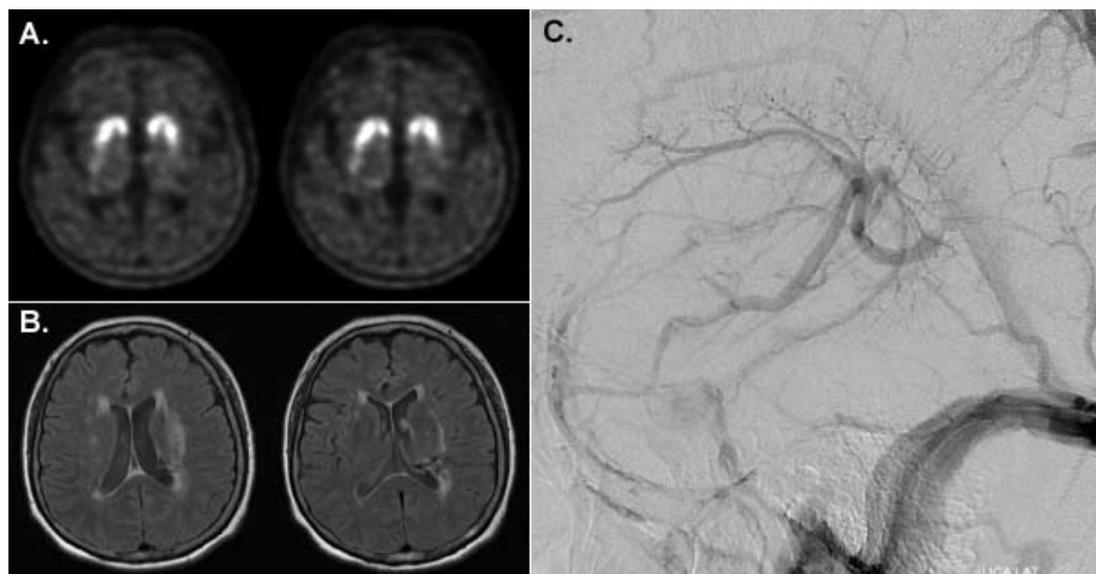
(A) F-18 FP-CIT PET shows symmetrical reduction of striatal tracer uptake in both posterior putamen. (B) Axial FLAIR MR image shows increased signal intensity in the white matter region drained by a developmental venous anomaly in the left basal ganglia. (C) Cerebral angiography during the venous phase confirms radiating medullary veins in the middle of the left basal ganglia region, suggesting a developmental venous anomaly.
